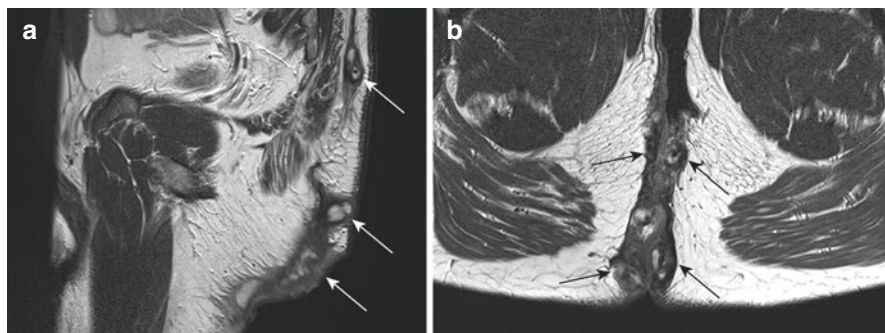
Extensive fistulas (*arrows*) on a sagittal T2-weighted sequence (a) and oblique axial T2-weighted sequence (b) in a patient with Crohn's disease for which differential diagnoses hidradenitis suppurativa and pilonidal sinus were considered. A firm distinction could not be made based on these images, but due to history and extensiveness, fistulizing Crohn's disease was most likely
